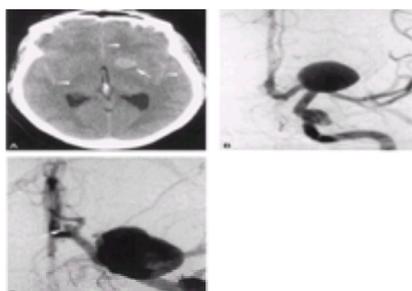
Subarachnoid hemorrhage caused by ruptured terminal internal carotid artery aneurysm. A: Nonenhanced computed tomography shows hyperdense aneurysm (arrow) and blood within interhemispheric and sylvian fissures (arrowheads). The ventricles are mildly enlarged and clot is present within the third ventricle. B: Left internal carotid artery arteriogram shows a 2-cm aneurysm arising from the termination of the internal carotid artery.
